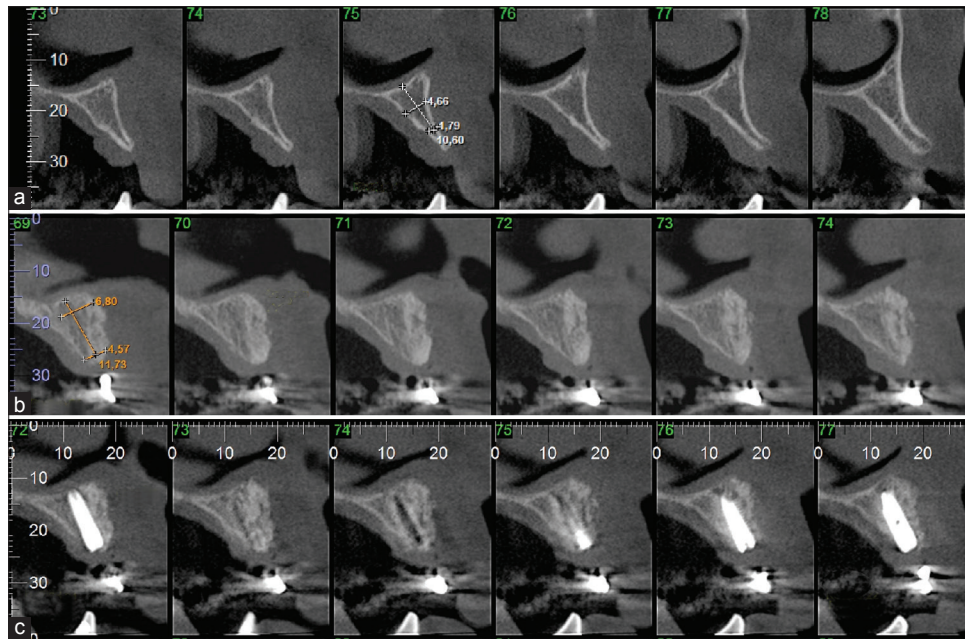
(a) Computed tomography image before treatment; (b) computed tomography image 4 months after treatment; (c) computed tomography image 8 months after treatment
